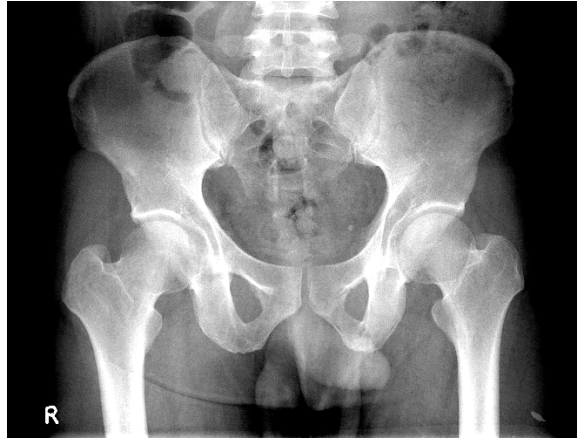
A radiograph example of the hip.
